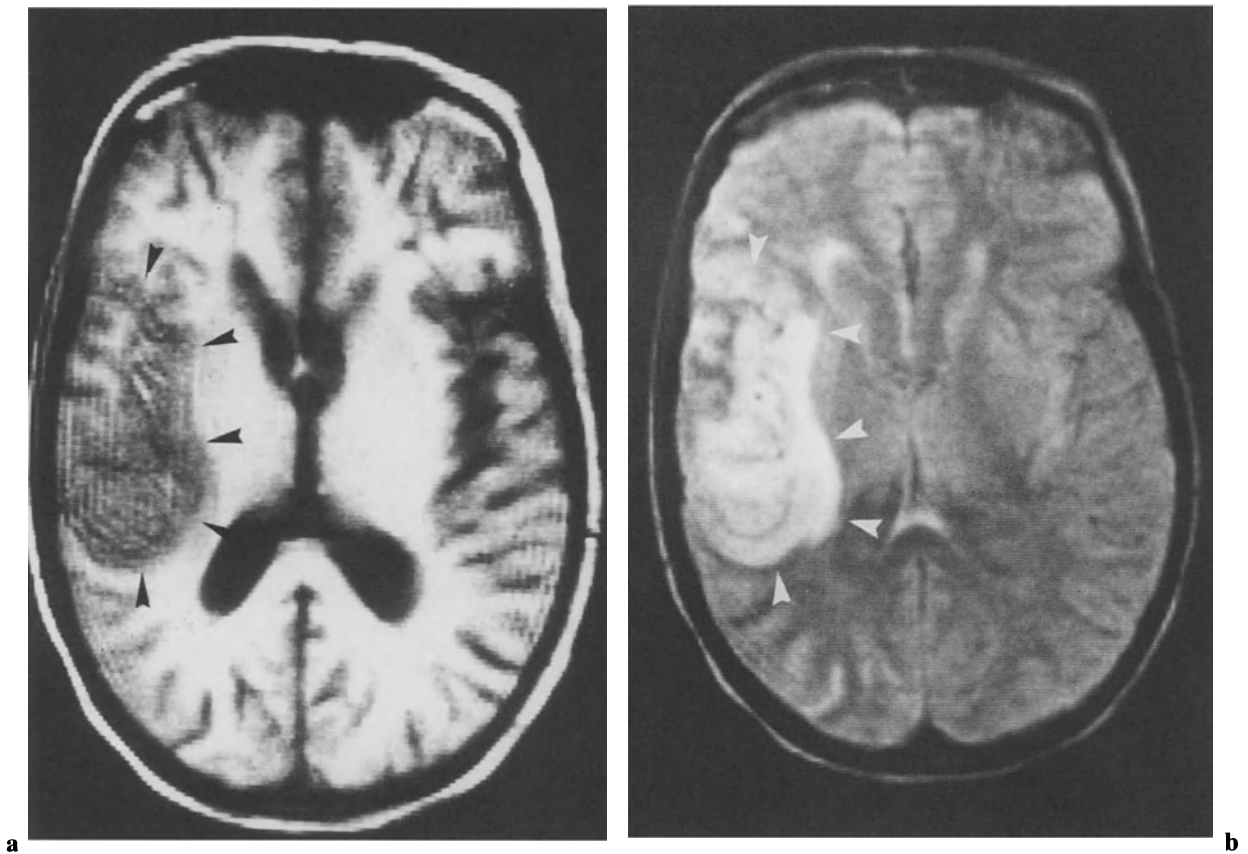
a, b. MRI appearance of an acute intracranial hemorrhage; same case as in Fig. 2.30 – however, the MRI examination was performed 4 days earlier, 2 days after the worsening of the patient's condition. a T1-WI shows a large, oval lesion (*black arrowheads*) adjacent to the region of the right basal ganglia, involving basal ganglia, white matter, and cortex. b At the T2-WI the lesion appears hyperintense. Taking the development of the lesion (*white arrowheads*) into account (note the difference to Fig. 2.30), a slowly progressing or a recurrent hemorrhage must be presumed
